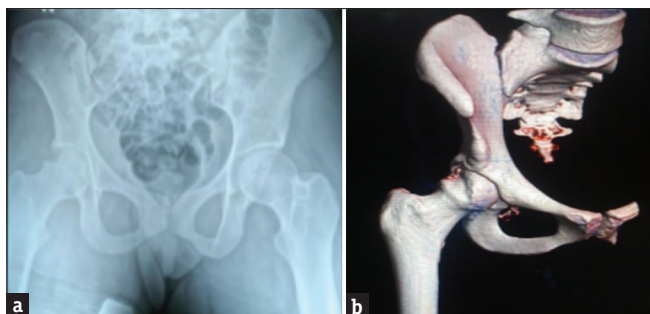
(a) Post reduction plain radiograph showing a deep defect outside the weight-bearing portion of the right femoral head. (b) Postreduction Computerized tomography scan showing an indentation fracture of the right femoral head sparing the weight-bearing portion
